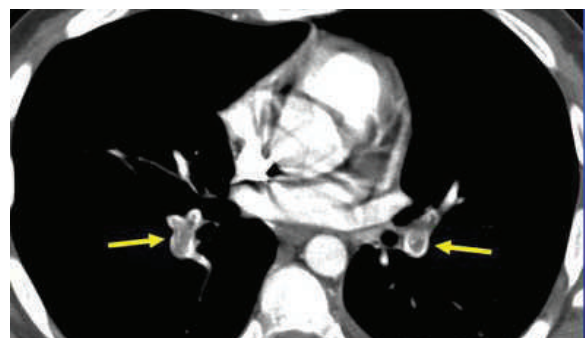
CT pulmonary angiogram shows pulmonary embolism
